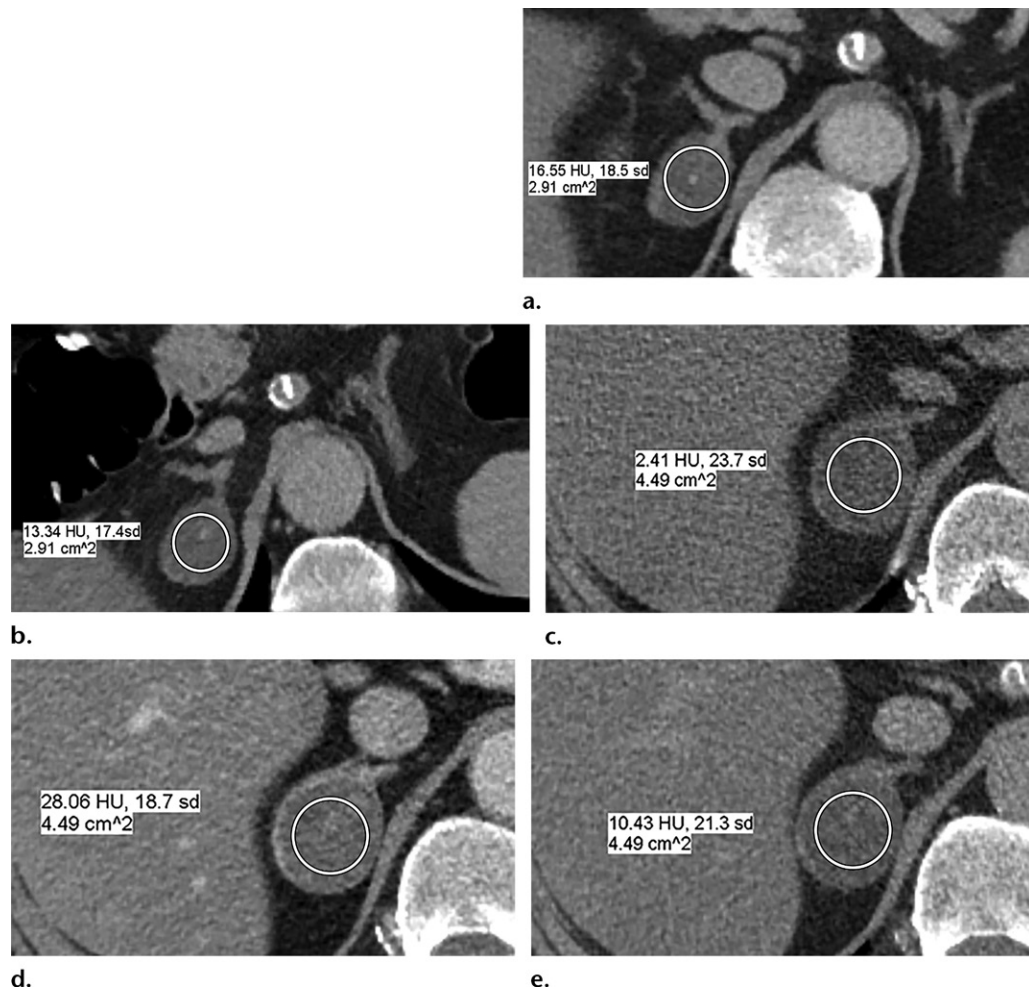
Altering delayed postcontrast imaging timing. (a, b) Axial contrast-enhanced CT colonography images obtained in the portal venous phase with the patient in the supine position (a) and approximately 3 minutes postcontrast with the patient in the prone position (b) show an incidental right adrenal lesion. The lesion remained indeterminate on the basis of the relative washout value on these images (19%), utilizing a prone delayed post-contrast acquisition, in this case obtained at 3 minutes. (c–e) Axial precontrast (c), portal venous phase (d), and delayed phase (e) images from the CT washout examination show the nodule with a relative washout value of 62.8% (absolute washout, 68.7%), resulting in the diagnosis of an adenoma. A proportion of adenomas take up to 15 minutes to demonstrate sufficient washout to satisfy the established washout cutoffs. In this case, the washout examination could have been terminated after the precontrast acquisition, if the examination had been monitored.
